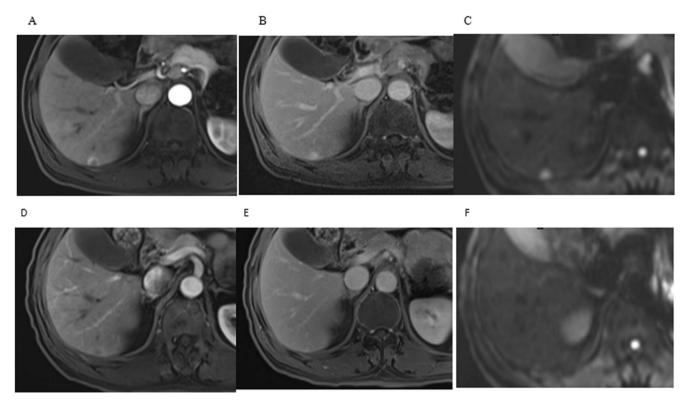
DCE-MRI manifestations of colorectal cancer liver metastasis before and after comprehensive treatment. A-C shows early dynamic contrast enhancement, late contrast enhancement, and DWI images before treatment, from which it can be seen that the early arterial lesions are ring-enhanced, the late arterial lesions are nodularly enhanced, and DWI shows a significant signal. D-F shows early dynamic contrast enhancement, late contrast enhancement, and DWI images after treatment, from which it can be seen that the annular enhancement of the early arterial lesions is significantly reduced, the nodule enhancement of the late arterial lesions is significantly reduced, and the DWI signal remains unchanged.
